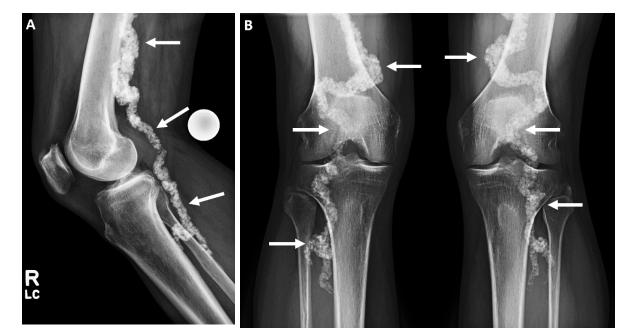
52-year-old male with Arterial Calcification due to Deficiency of CD73. (a) Lateral radiograph of the right knee and b) AP radiograph of the bilateral knees demonstrates marked tortuosity and extensive arterial calcification in the bilateral popliteal arteries (arrows).
